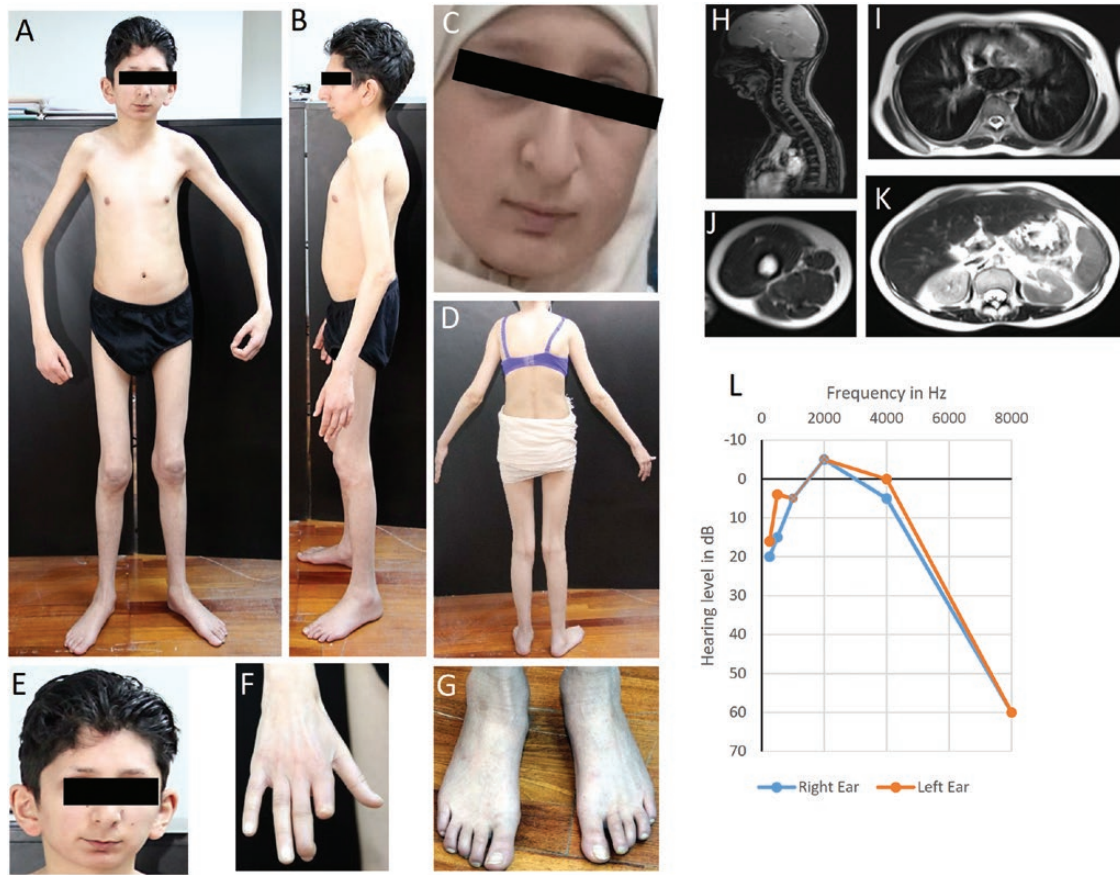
Clinical features of patient 1 (J100.3) with short stature, mandibular hypoplasia, osteoporosis, and short eyebrows, indicating progeroid syndrome. Anterior (A), and left lateral (B) views of the patient 1 (at age 18 years) showing thin limbs with a paucity of subcutaneous (sc) fat on the trunk and extremities and with normal hair on the scalp but lack of facial and body hair. (C) Anterior view of the face of patient 2 (J100.5) showing small mandible, beaked nose, and loss of lateral third of the eyebrows. (D) Posterior view of patient 2 showing thin limbs with paucity of sc fat on the extremities. (E) Anterior view of the face of patient 1 showing small mandible, beaked nose, and loss of lateral third of the eyebrows and lack of facial hair on the upper lip, chin, and cheeks. (F) Dorsal view of the right hand of patient 1 showing short index finger. (G) Dorsal view of the right foot of patient 1 showing incurved third toe. (H) Sagittal magnetic resonance imaging (MRI) of the head and neck through midline of patient 1 shows normal amount of sc fat in the scalp, neck, and upper chest. (I) Axial MRI of the chest at the level of the base of the heart of patient 1 showing normal sc fat anteriorly and posteriorly. (J) Axial MRI of the mid thigh of patient 1 showing normal amount of sc and intermuscular fat. (K) Axial MRI of the abdomen at the level of the kidneys of patient 1 showing normal amount of fat in the sc, intraperitoneal, and retroperitoneal (perinephric) region. (L) Audiometry of patient 1 showing moderate high frequency (8000 Hz) hearing loss in both the ears. Hearing level below 20 dB at a frequency is considered hearing loss.
